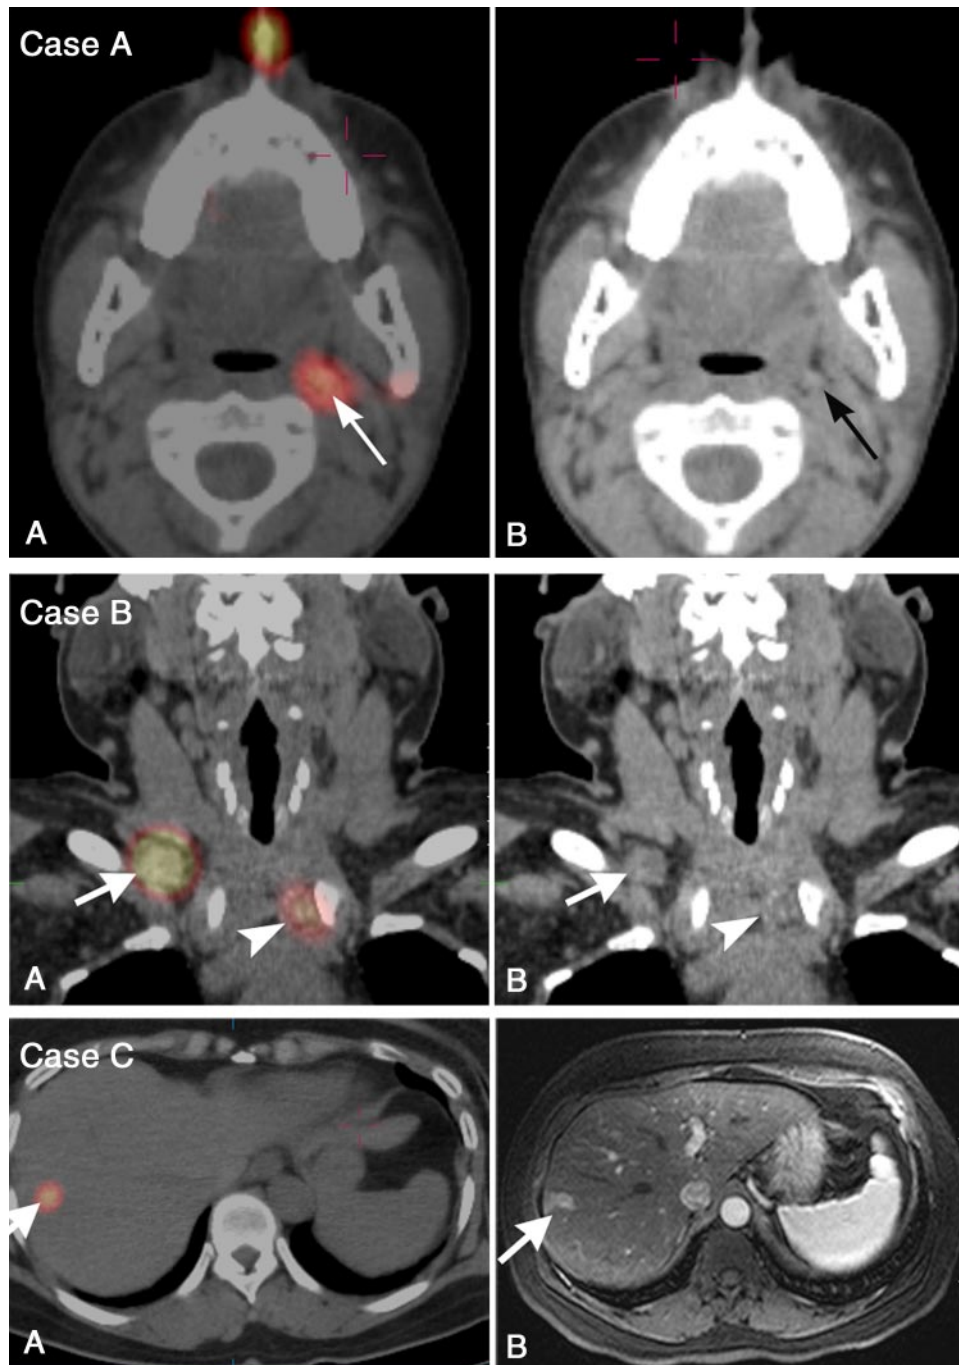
Case A: Diagnostic I-131 fused SPECT/CT (A) and CT (B) in a 14-year-old girl with multifocal microcarcinoma (0.8-cm and 0.4-cm papillary thyroid cancer) with extensive intrathyroidal angiolymphatic invasion, focal capsular invasion, and bilateral lymph node metastases, 13+/20 nodes resected; pT1a, N1b, M0, stage I. SPECT/CT revealed residual metastatic deposit in a 0.5-cm retropharyngeal lymph node located posterior to the left internal carotid artery (arrow). Follow-up scintigraphy at 6 months after administration of 1.85 MBq (50 mCi) ¹³¹I demonstrated lesion resolution and no evidence of persistent or recurrent disease. Case B: Diagnostic I-131 fused SPECT/CT (A) and CT (B) in a 54-year-old woman with multifocal papillary thyroid carcinoma (largest focus 1.6 cm), confined to the thyroid, margins free; pT1b, Nx, M0, stage I. SPECT/CT revealed metastatic deposits corresponding to 1.7-cm right retroclavicular node (arrow) and 0.8-cm node at the thoracic inlet (arrowhead); pT1b, N1b, M0, stage IV A. Considering the volume of the larger metastatic deposit, the patient was referred for surgical resection prior to ¹³¹I therapy. Case C: Diagnostic I-131 fused SPECT/CT (A) and magnetic resonance imaging (B) in a 56-year-old woman with 1.2-cm papillary thyroid cancer without capsular invasion, no extrathyroidal extension, and negative surgical margins; 0/3 central nodes resected; pT1b, N0, M0, stage I. SPECT/CT revealed focal activity in the liver (arrow) corresponding on magnetic resonance imaging to a 0.8-cm arterially enhancing lesion, consistent with hepatic metastasis; restaging: pT1b, N0, M1, stage IV C. Follow-up scintigraphy at 6 months after administration of 7.4 MBq (200 mCi) ¹³¹I demonstrated lesion resolution and no evidence of persistent or recurrent disease.
